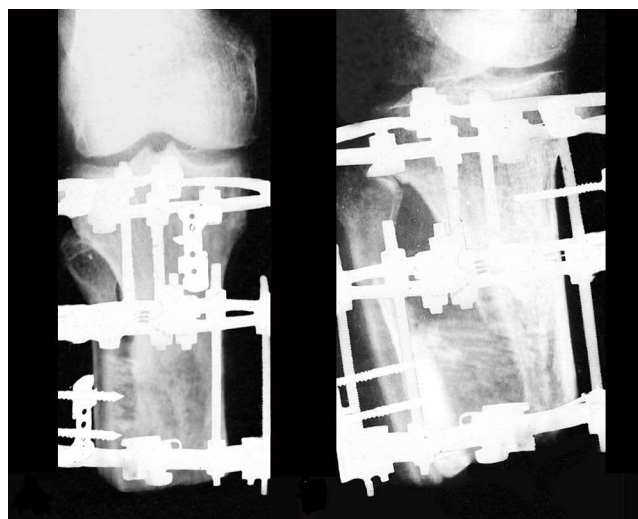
Radiographs of the residual limb in 2 projections 3 months after surgery (17.05.2020).
